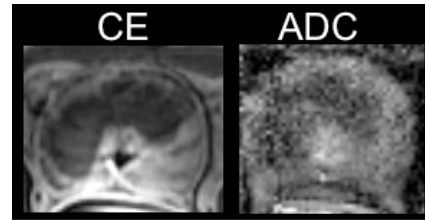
Example contrast enhanced and apparent diffusion coefficient (ADC) maps of the same experiment shown in Fig. 1, demonstrating the same area treated by high intensity ultrasound.
